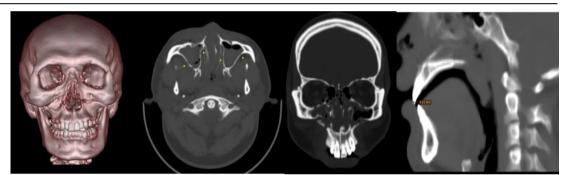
Head CT scan of a 26 years old male involved in motorcycle accident showed fracture on bilateral pterygoid plate, lateral margin of nasal fossa and anterior-medial-lateral sinus wall (arrow) which causes a floating palatum shape which is a Le Fort fracture type I. Notice that malocclusion also happens to the patient.
